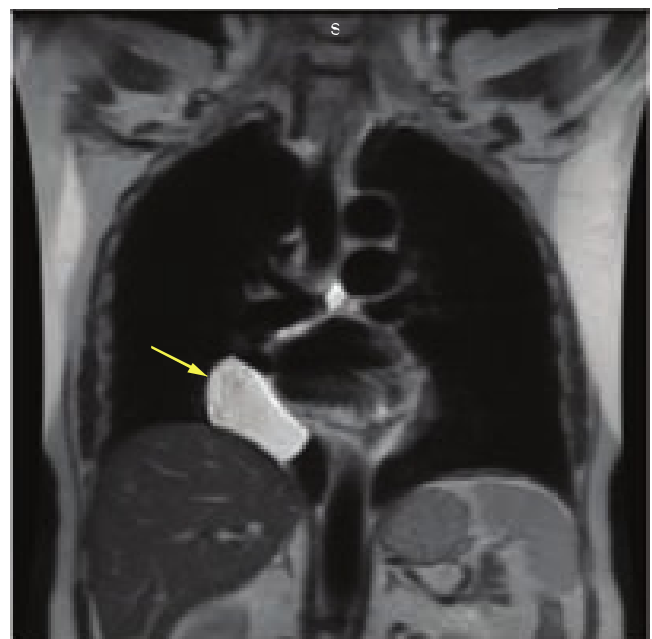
Magnetic resonance imaging coronal plane across the chest demonstrating contrast enhancement due to a pericardial cyst (arrow).
